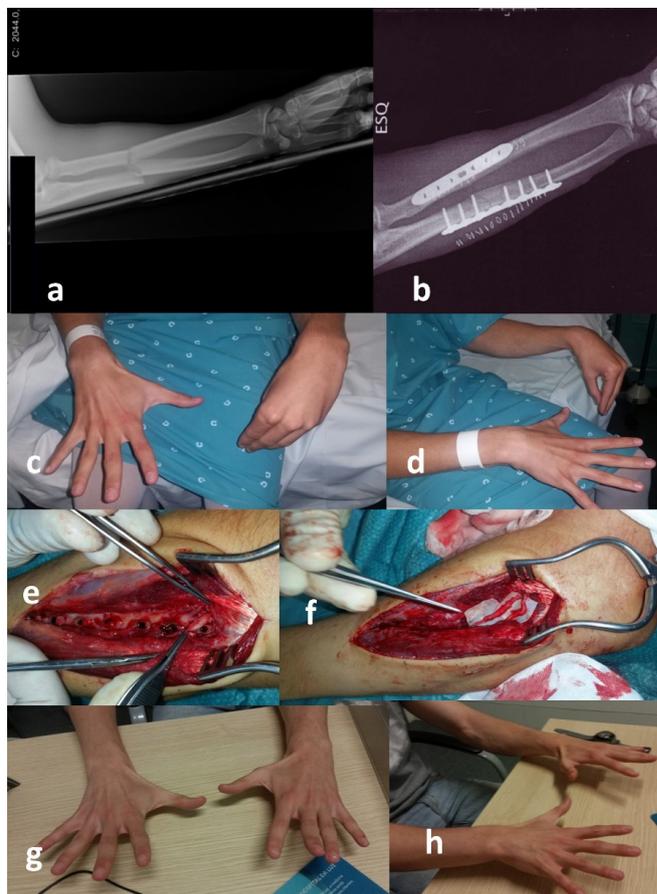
Seventeen-year-old boy with iatrogenic paralysis of the left radial nerve following osteosynthesis of a fracture of the radius, treated by the author at Hospital da Luz Lisboa. Treatment consisted of implant removal, neural release, and microsurgical reconstruction with two cables of sural nerve. a, b: Preoperative X-rays c, d: Preoperative views showing complete paralysis of the left radial nerve e: intraoperative view with the lower forceps marking the proximal stump of the deep branch of the radial nerve, after removal of the osteosynthesis plate and screws f: reconstruction with two cables of sural nerve g, h: Postoperative views show complete functional recovery at six months.
